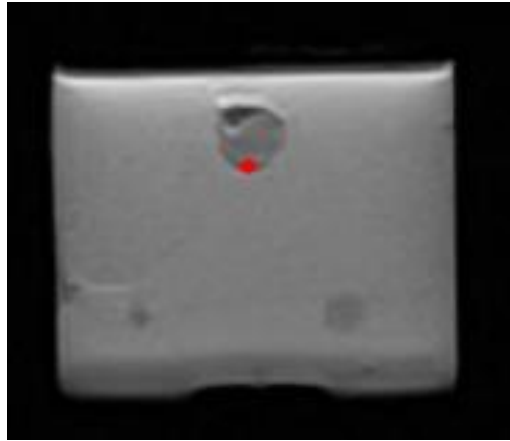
Target location as set on MRI image in the biopsy software (large tumour).
